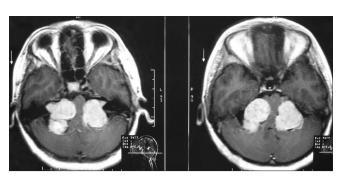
Contrast-enhanced MRI showing bilateral VS
